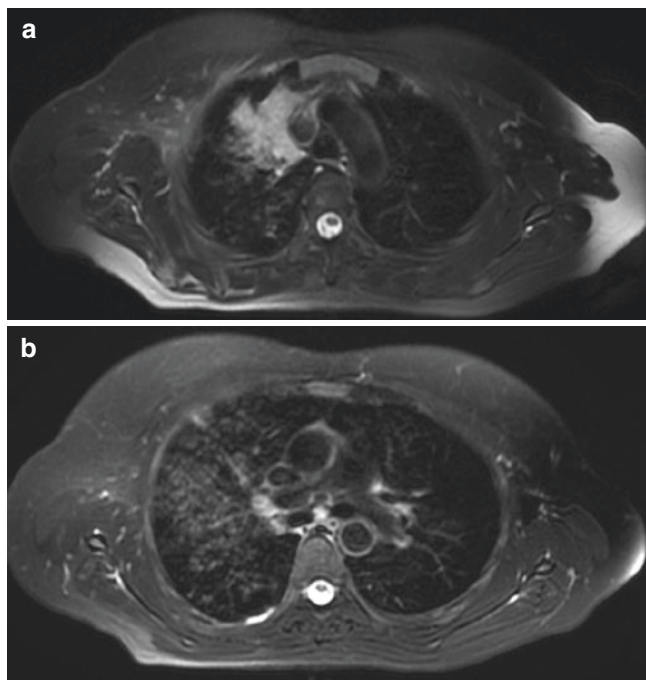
A 16-year-old girl with tuberculosis. (a) Axial T2-weighted FRFSE MR image with fat suppression shows parenchymal consolidation in the right upper lobe. (b) Axial T2-weighted FRFSE MR image with fat suppression acquired at a lower level demonstrates mucus plugging with “tree in bud” appearance in the right lung
